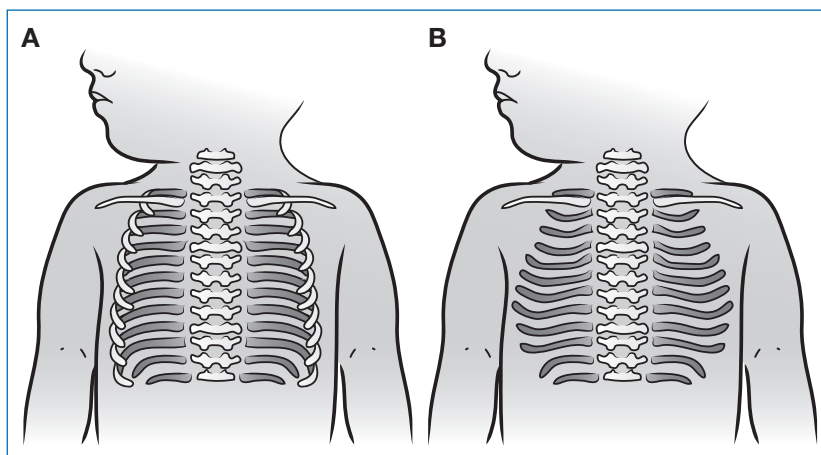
Skeletal position in a normally positioned radiograph (A) and in a film obtained with cephalad positioning of the x-ray tube (B).
